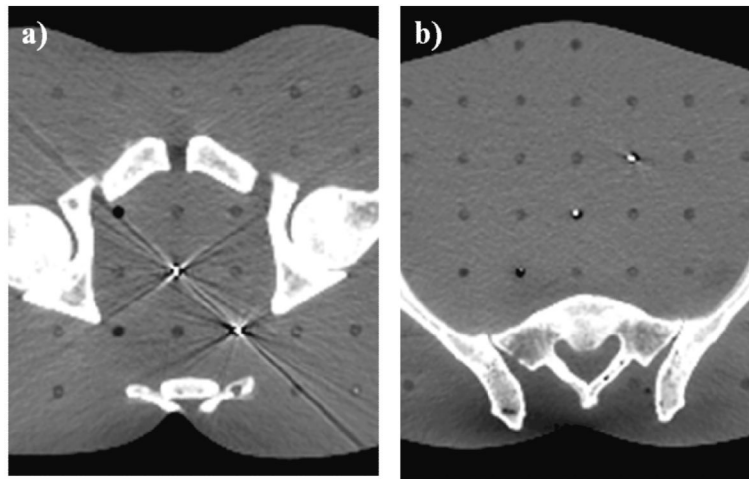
CT slice image (120 kVp, 250 mAs, 2.5 mm slice thickness, 1.2695 mm pixel spacing) demonstrating (a) clearly visible streak artifacts due to the C-coated W rod (center) and carbon coated Pt (bottom right) fiducials and (b) minimal streak artifacts due to the C-coated ZrO₂ barbell (top right), the C-coated ZrO₂ 3 bump rod (center), and the long C-coated ZrO₂ 3 bump rod (bottom left).
